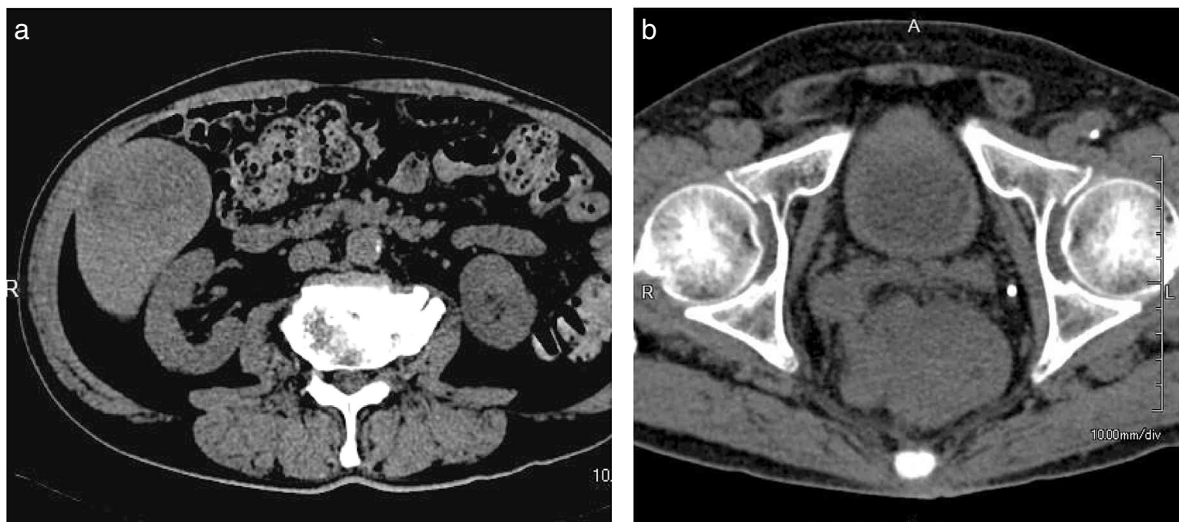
Abdominal computed tomography showed the low density tumor shadows of the rectum and the right hepatic lobe.
